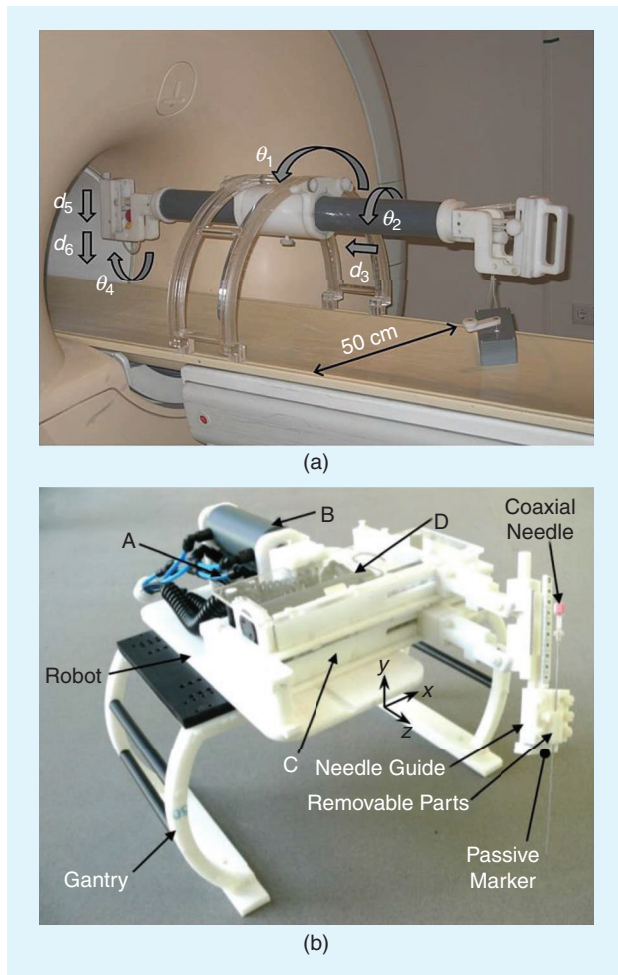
Typical table-mounted robots with an arch gantry. (a) A manually actuated table-mounted robot [93]. (b) A robot for MRI-guided liver ablation [80]. (Source: Wiley-Liss; used with permission.)
